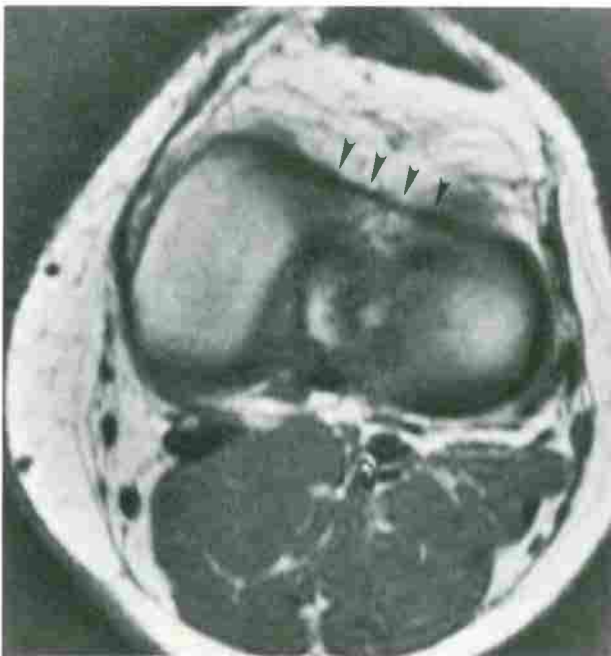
Transverse meniscal ligament. Axial T1-weighted (TR/TE, 600/20) image demonstrates the transverse meniscal ligament (arrowheads) extending between the anterior horns of the medial and lateral menisci.
